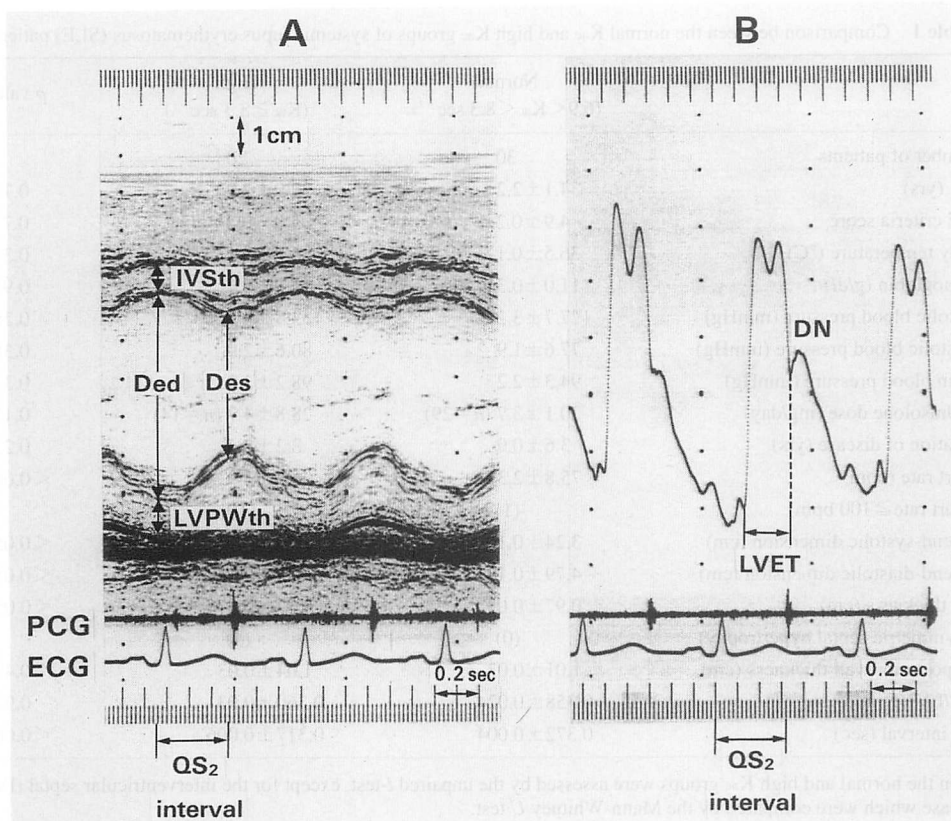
Representative M-mode echocardiogram (A) and carotid pulse wave tracing (B)
